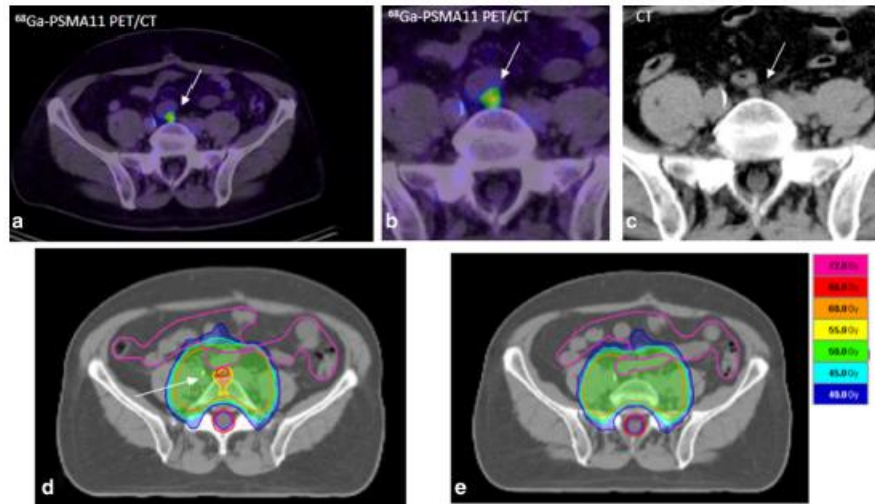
圖 二十二、Ga-68-PSMA-11 骨盆腔 PET 影像 (作者摘錄)
